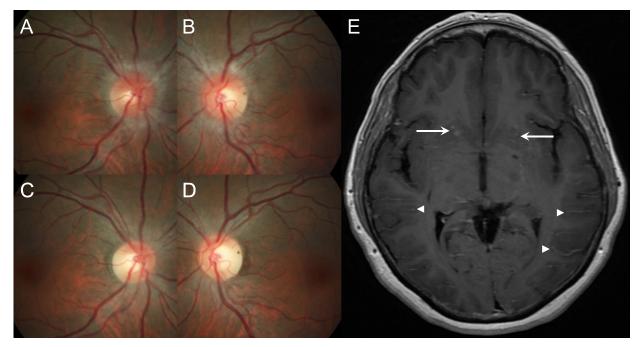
Patients with Cryptococcus neoformans. Mild disc edema is evident (A: OD; B: OS) with resolution 5 weeks later (C: OD; D: OS). Magnetic resonance imaging T1 postcontrast (E) shows leptomeningeal enhancement (arrowheads) and multiple enhancing basal ganglia puncta (arrows).
